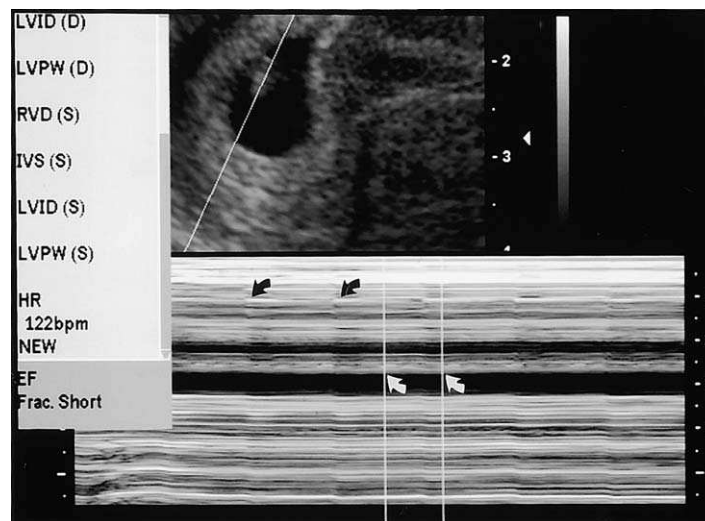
M-mode ultrasound identifies and measures embryonic cardiac activity (white arrows) and maternal cardiac activity (black arrows).
